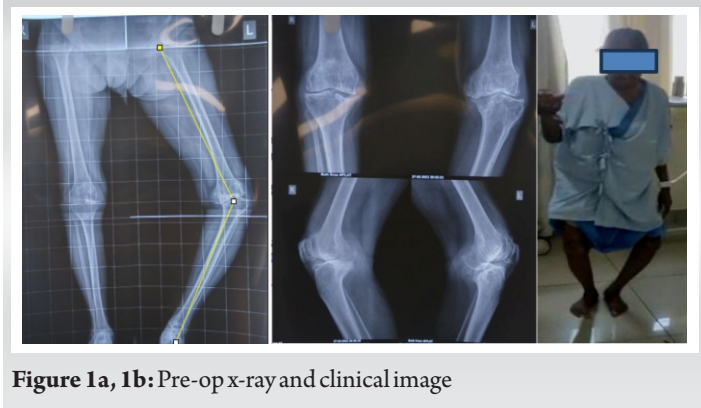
Pre-op x-ray and clinical image
